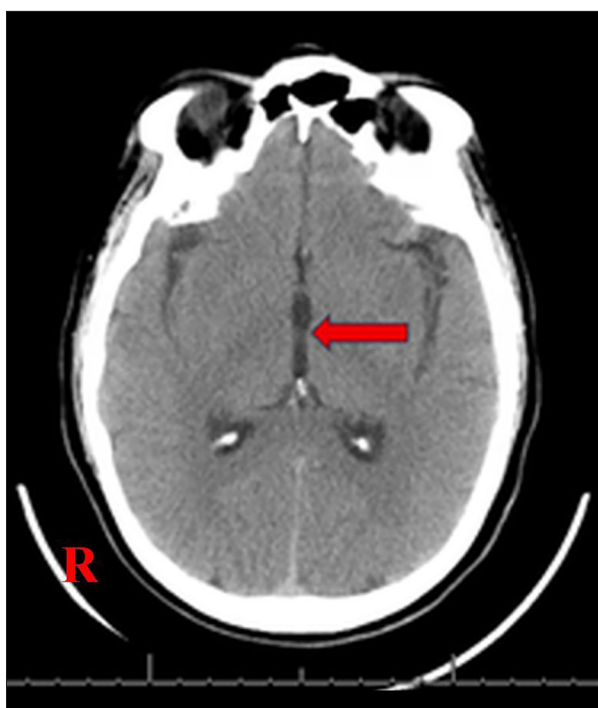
Computed tomography axial image of the brain on admission demonstrating no obvious pathology. The arrow points to the third ventricle. 'R', right side.
